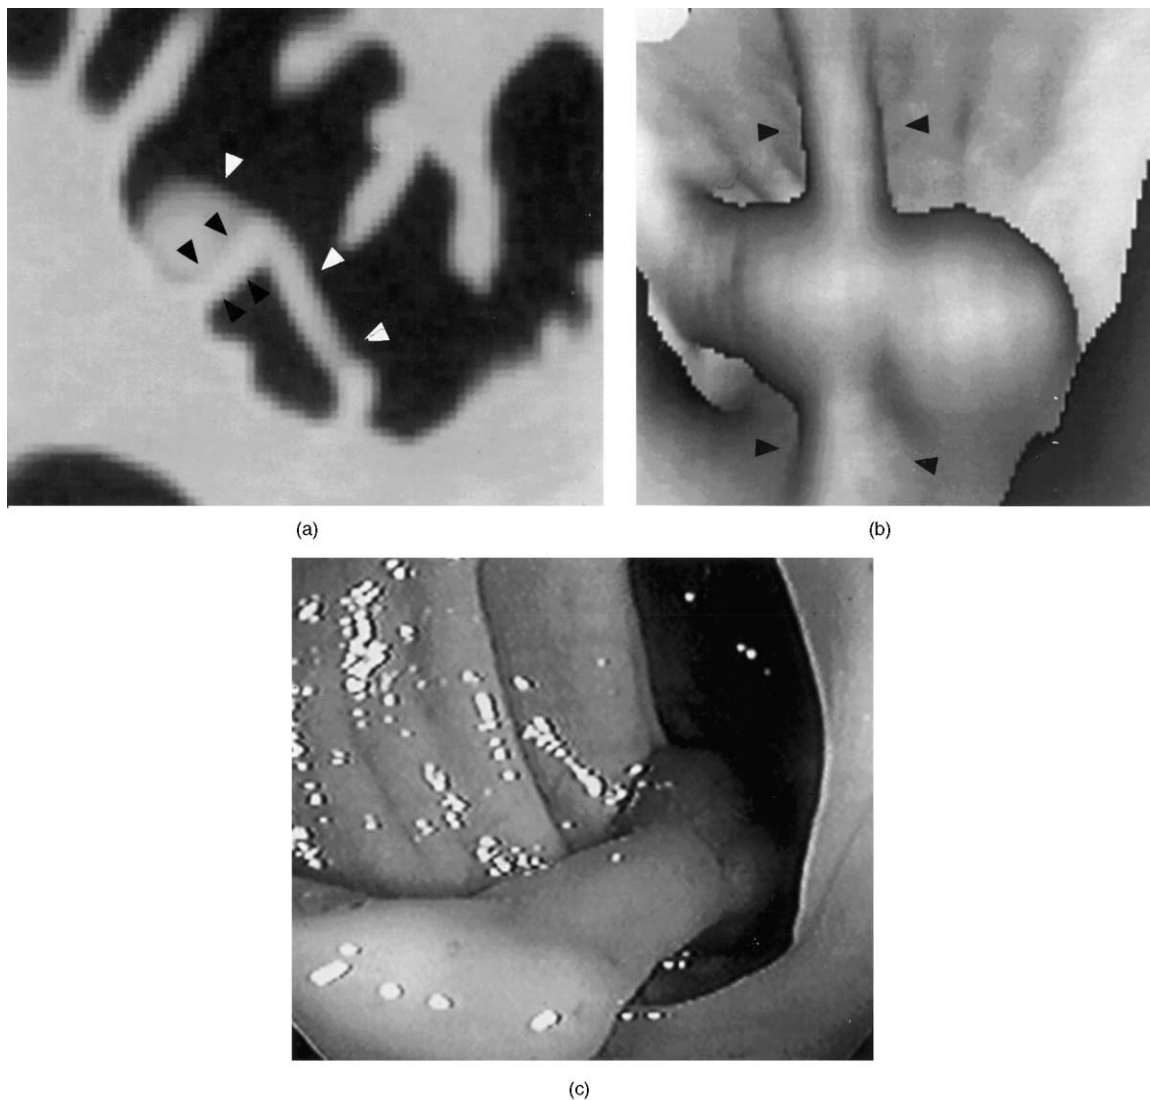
Pedunculated polyp. Axial computed tomography colonography (CTC) image shows a pedunculated polyp (white arrowheads) draped over a haustral fold (a, black arrowhead). The corresponding 3D endoluminal view demonstrates the polyp, but the rendering does not show that the polyp is separate from the haustral fold (b, black arrowheads). The endoscopic view of the polyp (c) resembles the 3D endoluminal rendering (reprinted by permission from the *American Journal of Roentgenology*).
